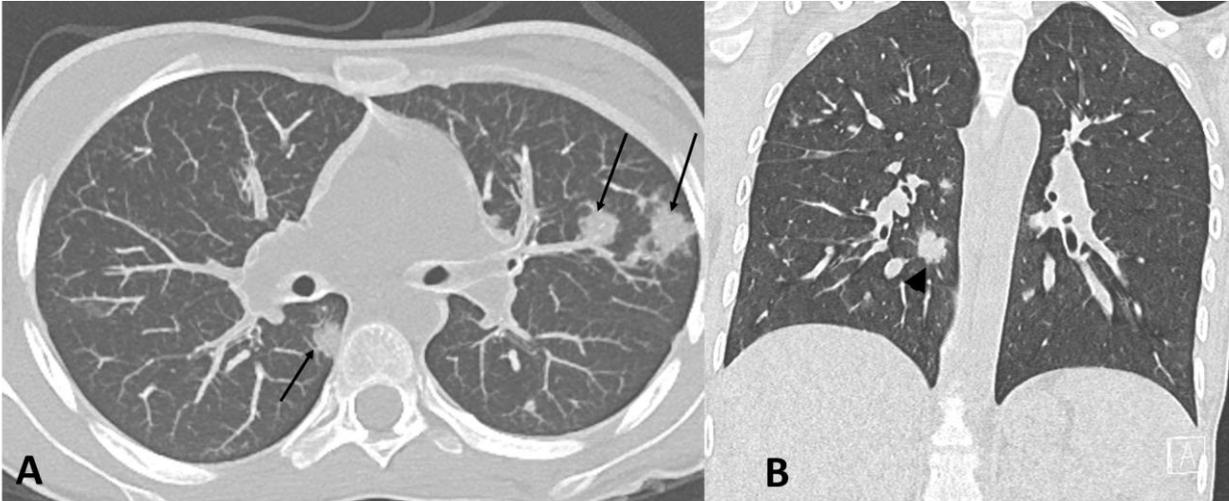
High-resolution CT scan of lungs with axial and coronal images (a and b) in lung-window settings- shows multiple bilateral nodular opacities, most of them were peripheral and subpleural (thin black arrows). (b)The nodules show ill-defined borders with ground-glass halo (Arrowhead).
